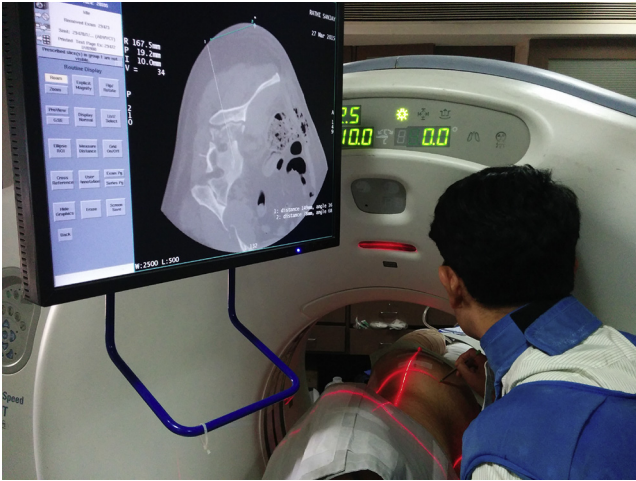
Marking the skin entry point under CT scan guidance.
